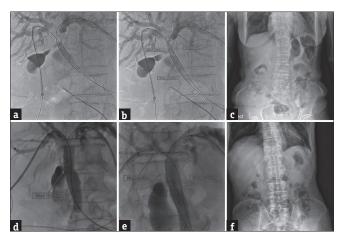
Compound tri-metal stent placement for malignant hilar biliary obstruction. (a-c) Images from a patient with perihilar cholangiocarcinoma (Bismuth–Corlette classification IV). Percutaneously placed guidewires that enabled stent placement (a). Triple stenting of both intrahepatic and extrahepatic bile ducts (b). Abdominal radiograph of the stents (c). In this case, after deployment of the first stent (4 cm in length and a diameter of 10 mm), second and third stents (6–8 cm in length and a diameter of 8 mm) were sequentially placed. (d-f) Images from a patient with perihilar cholangiocarcinoma (Bismuth–Corlette classification IIIb). Deployment of the first stent of 4 cm length and a diameter of 10 mm (d). Sequentially introduced second and third stents, which had a 6–8 cm length and diameter of 8 mm (e). Y-configured radiograph obtained after compound tri-metal stent placement (f)
